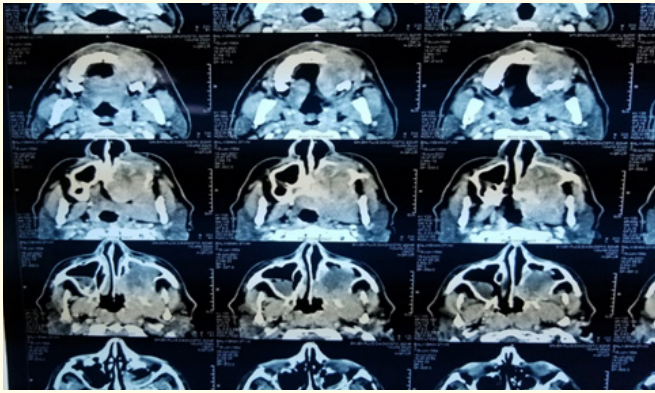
Maxillary cross-sectional radiograph showing radiopacity w.r.t 23, 24, 25, 26, 27, 33, 36,46.
